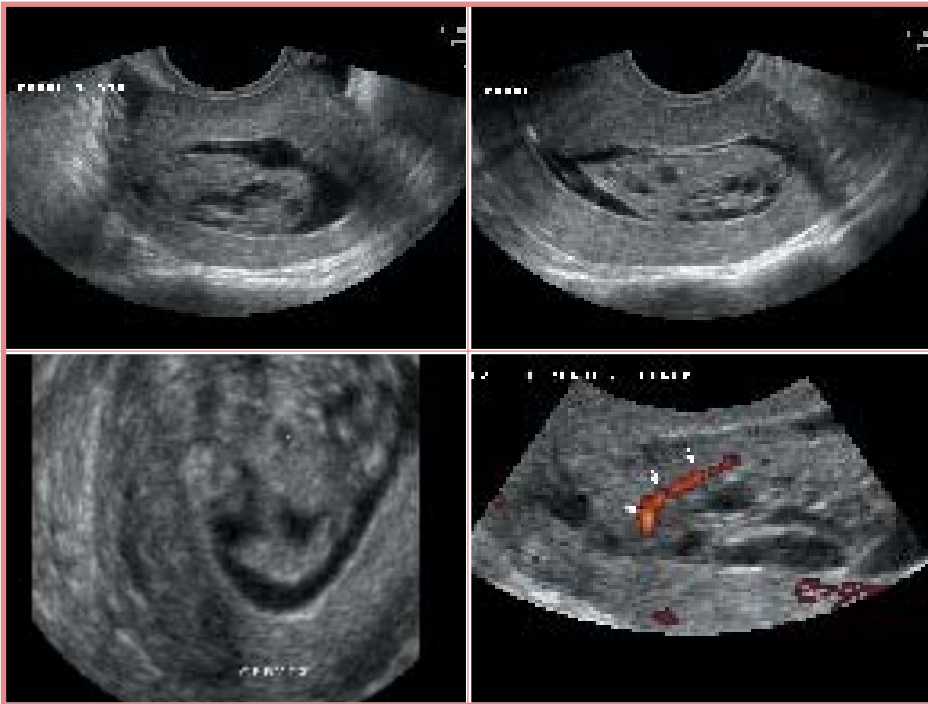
Uterine anomalies can be difficult to diagnose on 2D ultrasound, however are well differentiated on 3D ultrasound. A subseptate uterus can be difficult to distinguish from the anatomical variant of arcuate uterus and a fully septated uterus should be distinguished from a bicornuate uterus, as each has different management options. The patient above presented with a history of recurrent miscarriage. The coronal ultrasound demonstrates a normal convex uterine fundus with a septum extending from the fundus to the cervix. This is the most common anomaly associated with recurrent miscarriage and can be treated hysteroscopically with resection of the septum.
